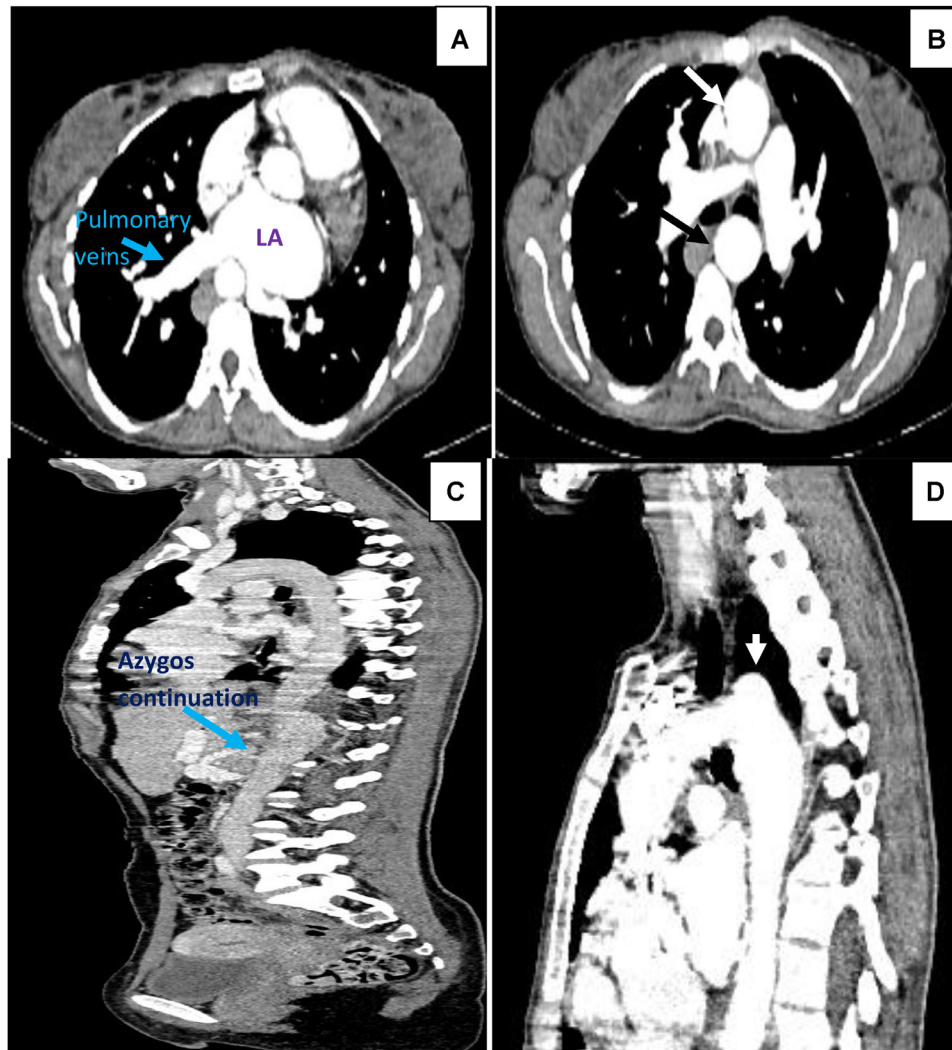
The thoraco-abdominal CTA revealed dilation of the left atrium (LA) and pulmonary veins (A), along with enlargement of the ascending aorta (White arrow “B”) and the proximal portion of the descending aorta (black arrow “B”). A large azygos vein was found to replace the inferior vena cava (IVC), with azygos continuation and absence of the retrohepatic segment of the IVC (C). The aortic arch, presenting a gothic-type configuration with a sharp angle at its peak (D), requires special attention, as it may exacerbate arterial hypertension, thereby increasing the risk of perioperative hypertension.
